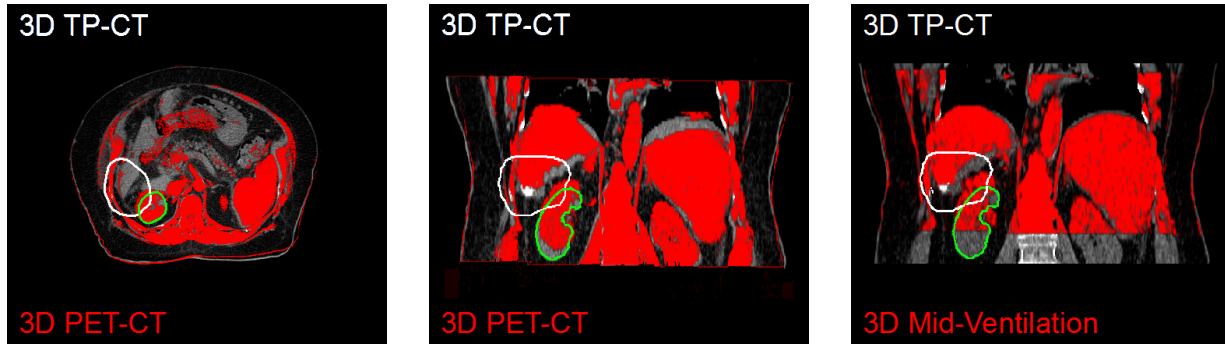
Comparison of different 3D CT images of patient L4. The 3D TP-CT is shown as grey-scale and overlaid by the rigidly registered 3D PET-CT (red) in the transaxial (left) and coronal (middle) plane, as well as by the calculated 4D TP-CT-based mid-ventilation CT (red, right). In the region of the PTV (white contour) and the right kidney (green contour), the TP-CT represents a phase of significantly deeper inspiration, close to 100% exhale. PTV and kidney are thus shifted caudally with respect to the 3D PET-CT and the mid-ventilation CT, which both show a comparable motion state near 20% exhale in the PTV region.
